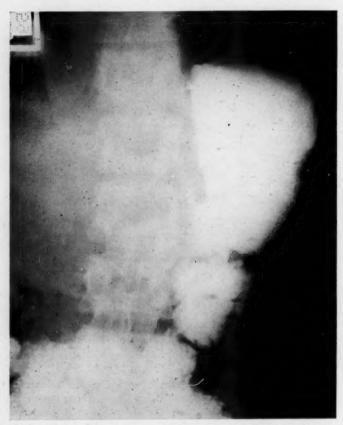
Roentgenogram of the stomach, seven and one-half months after partial resection, revealing a well-functioning stoma.
